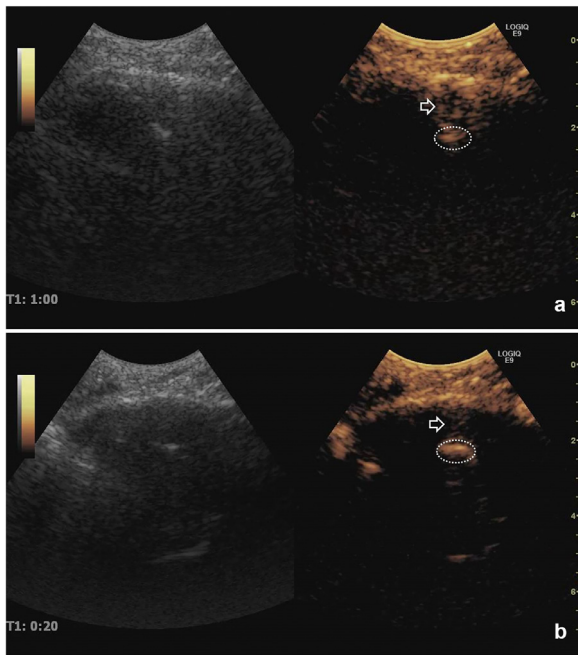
The effect of hemostasis of HA group. (a) After the injection of the HA, we also kept on observing by the transcranial CEUS for 10 s. At the 10 s after the local drug therapy, we found that the active bleeding became much weaker (as shown by the white arrow) and the range of hematoma became further smaller (as shown by the white dotted circle). (b) We observed the ICH again by the transcranial CEUS after the first contrast agents totally disappeared; the image of ICH (as shown by the white dotted circle) could also be clearly observed but the active bleeding (as shown by the white arrow) could not be clearly identified, which strongly suggested that the effect of hemostasis by HA injection was satisfactory. HA = hemocoagulase atrox; CEUS = contrast-enhanced ultrasound; ICH = intracerebral hematoma.
